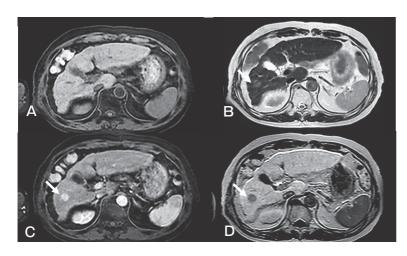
On abdominal magnetic resonance imaging (MRI), the large lesion was not observed with T1-weighted imaging (A) but was observed as a hyperintense mass on T2-weighted imaging (B) in the anterior inferior portion (S5) of the liver. The same lesion was observed as a hyperintense mass in the artery phase (C) and as a hypointense mass in the hepatobiliary phase after the administration of Gd-EOB-DTPA.
